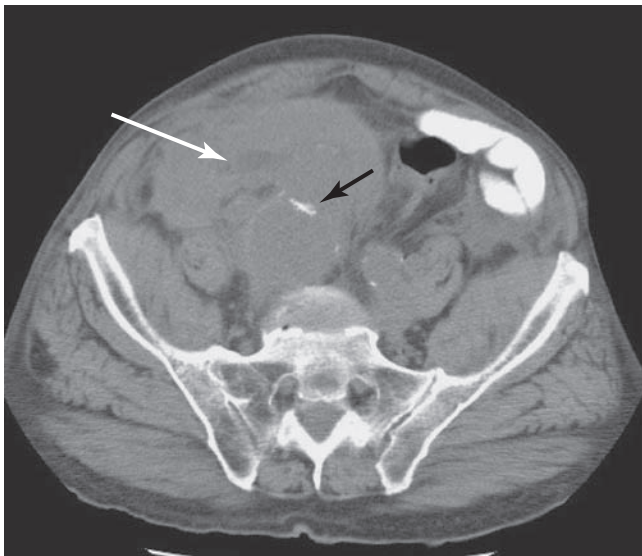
Noncontrast CT scan demonstrating calcium in the wall of the aorta (*dark arrow*) and retroperitoneal hematoma with fresh blood (*white arrow*) diagnostic of ruptured abdominal aortic aneurysm (AAA).
